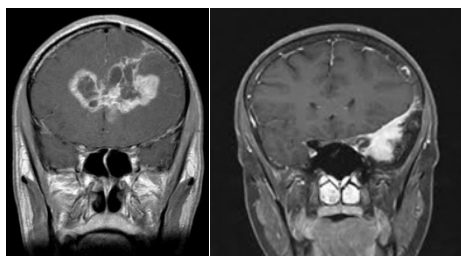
Sample MRI Images; (a). MRI with tumor, (b). MRI without Tumor
